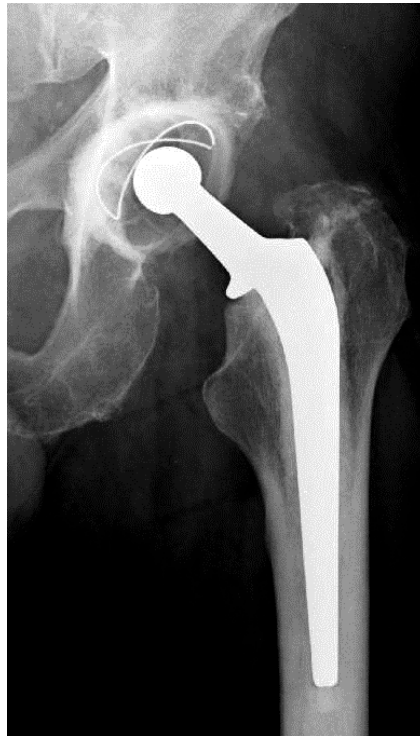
Radiograph of a total hip arthroplasty.
